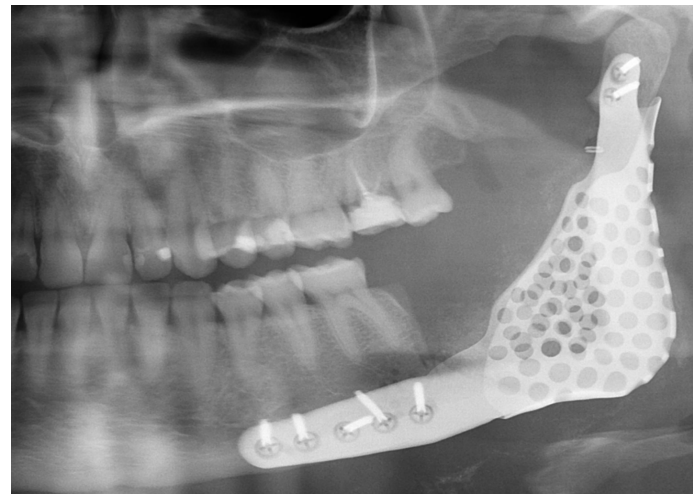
Post-operative panoramic radiograph (cropped) of the reconstructed mandible with the PSI-plate made of titanium.
